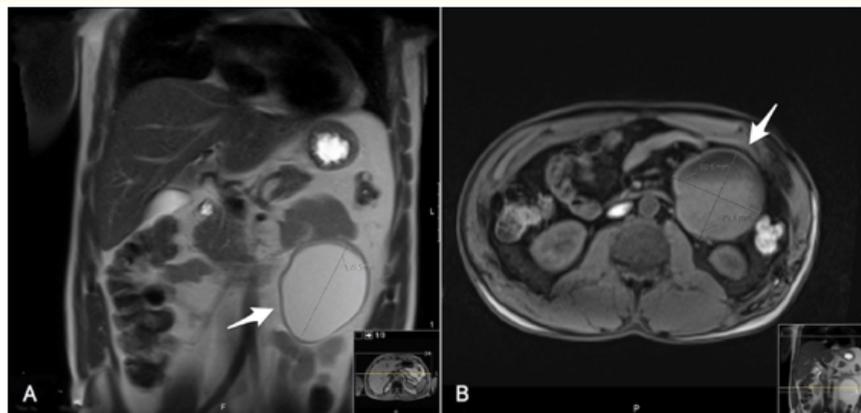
MRI revealing an 8 x 7,5 cm mesenteric cyst (white arrow). (A) coronal plane, T2-weighted; (B) axial plane, T1-weighted.
